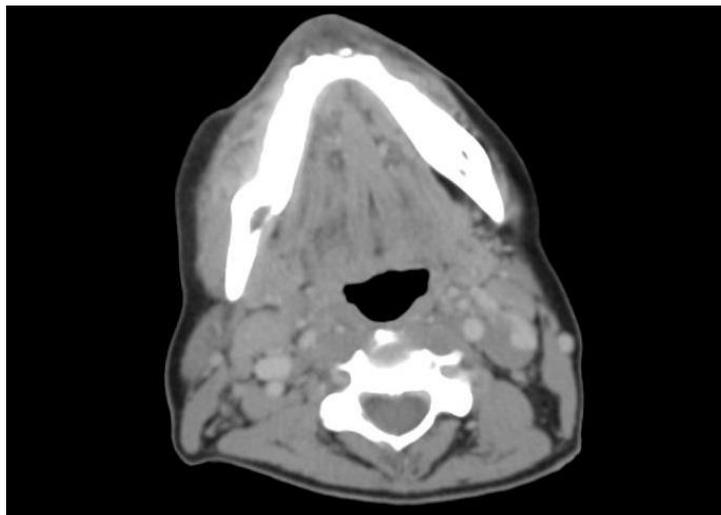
CT scan of Oral cavity showing malignant lesion in right RMT region with mandible erosion
